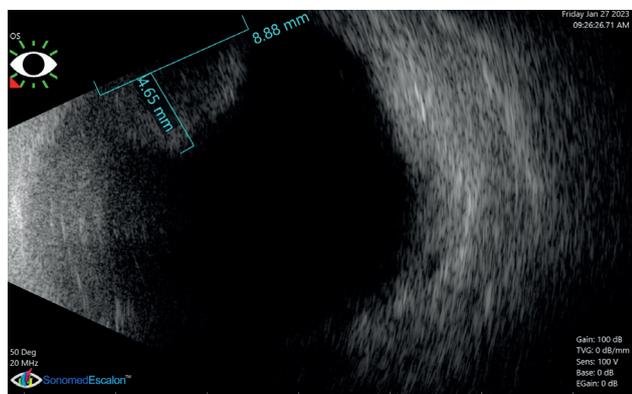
Ultrasound image with prominent spherical lesion in the upper temporal quadrant
